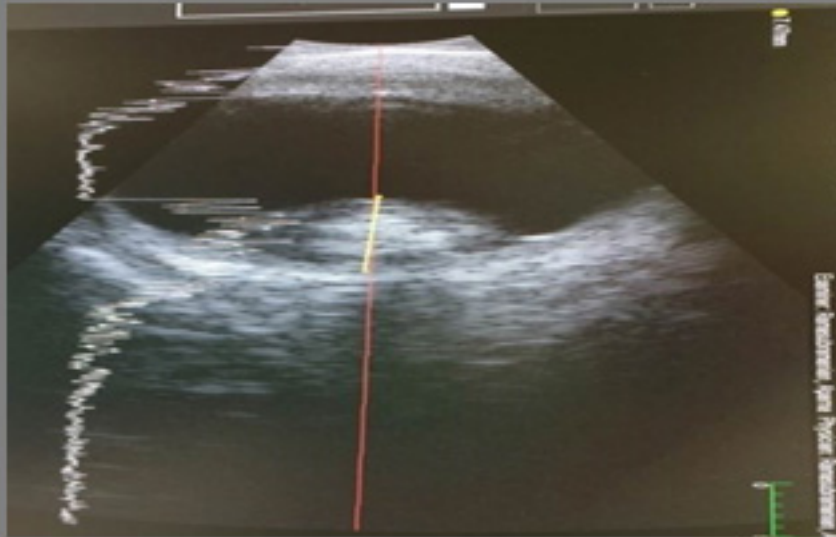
Ultrasound shows retinoblastoma in 3 months baby with unilateral cataract.
